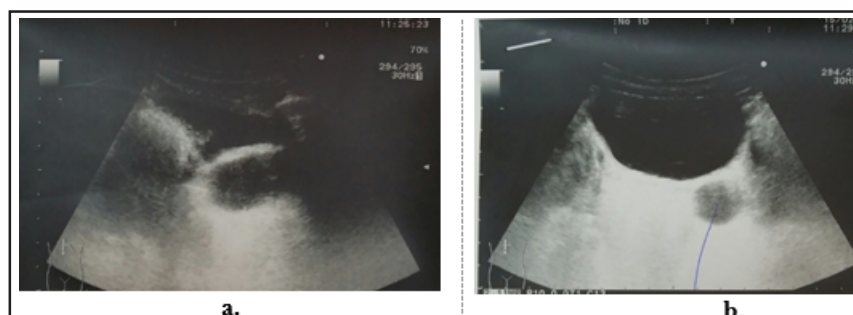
Ultrasound of the urinary system (a.transverse and b.sagittal)
